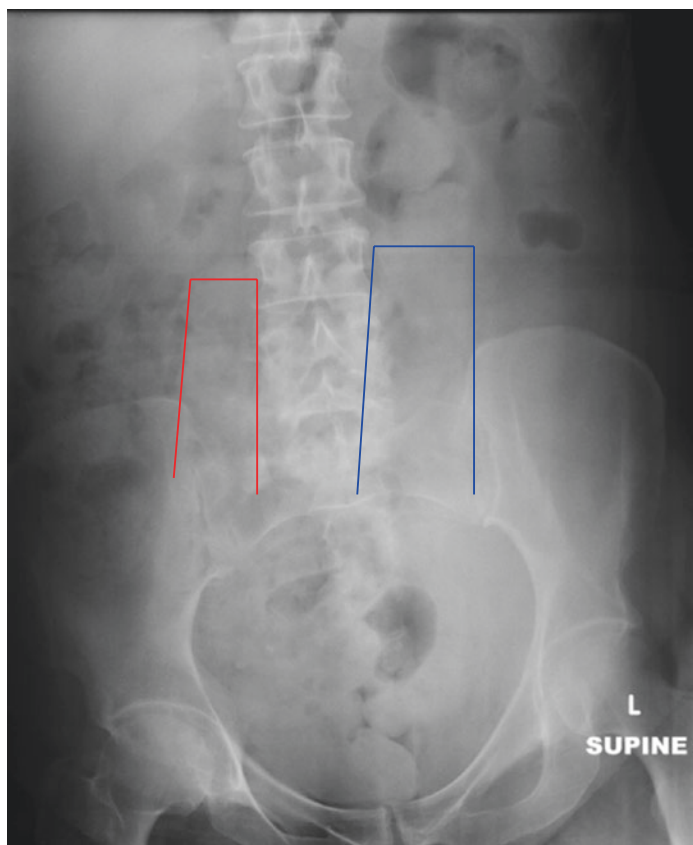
Abdominal x-ray demonstrating subtle radiographic findings of a psoas abscess. Here the psoas shadow is thicker on the left (blue outline) than the right (red outline). This finding is not sensitive or specific for a psoas abscess, but is an indication that advanced imaging is needed
